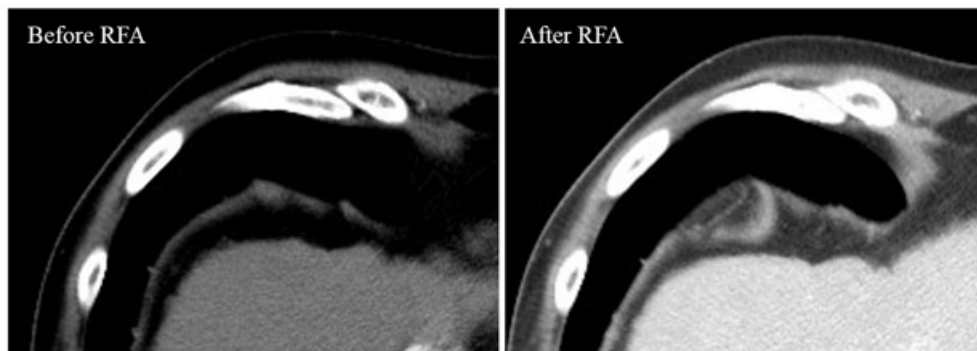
Abdominal CT before radiofrequency ablation (RFA) showed intact diaphragm and the diaphragm was disrupted at 7 months after RFA.
